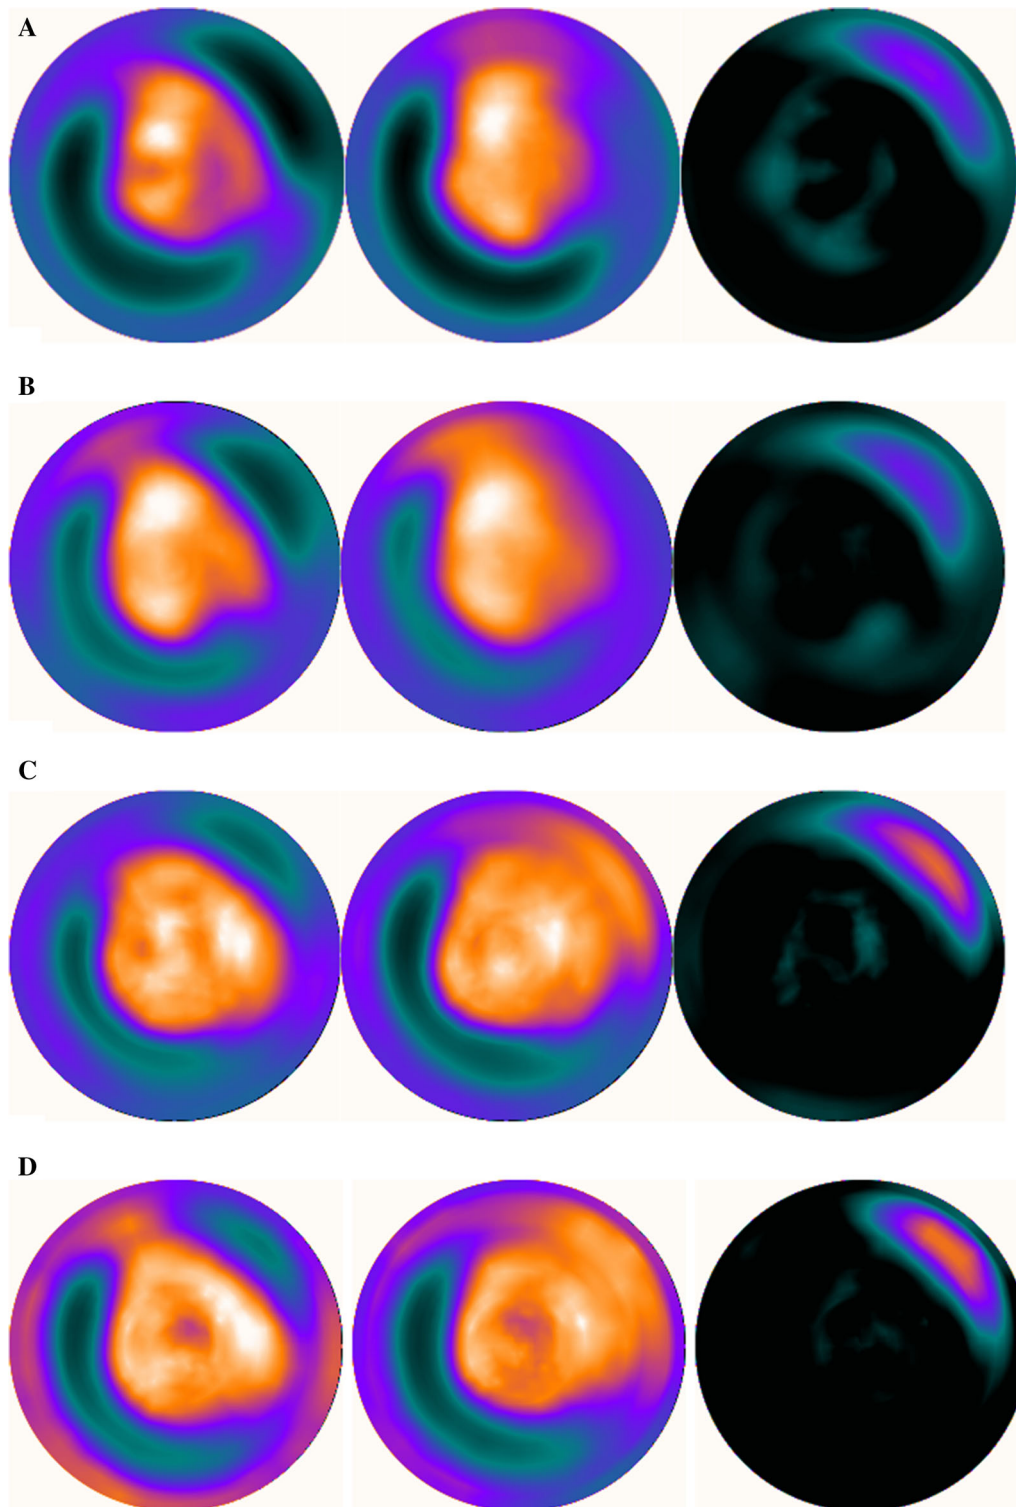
Single-isotope (separate ^{123}I and $^{99\text{m}}\text{Tc}$) acquisitions and mismatch on DNM 530c (A) and DSPECT (C) and simultaneous dual-isotope (^{123}I and $^{99\text{m}}\text{Tc}$) acquisitions and mismatch on DNM 530c (B) and DSPECT (D) presented as the bull's eye polar maps of the 22-min acquisitions.
